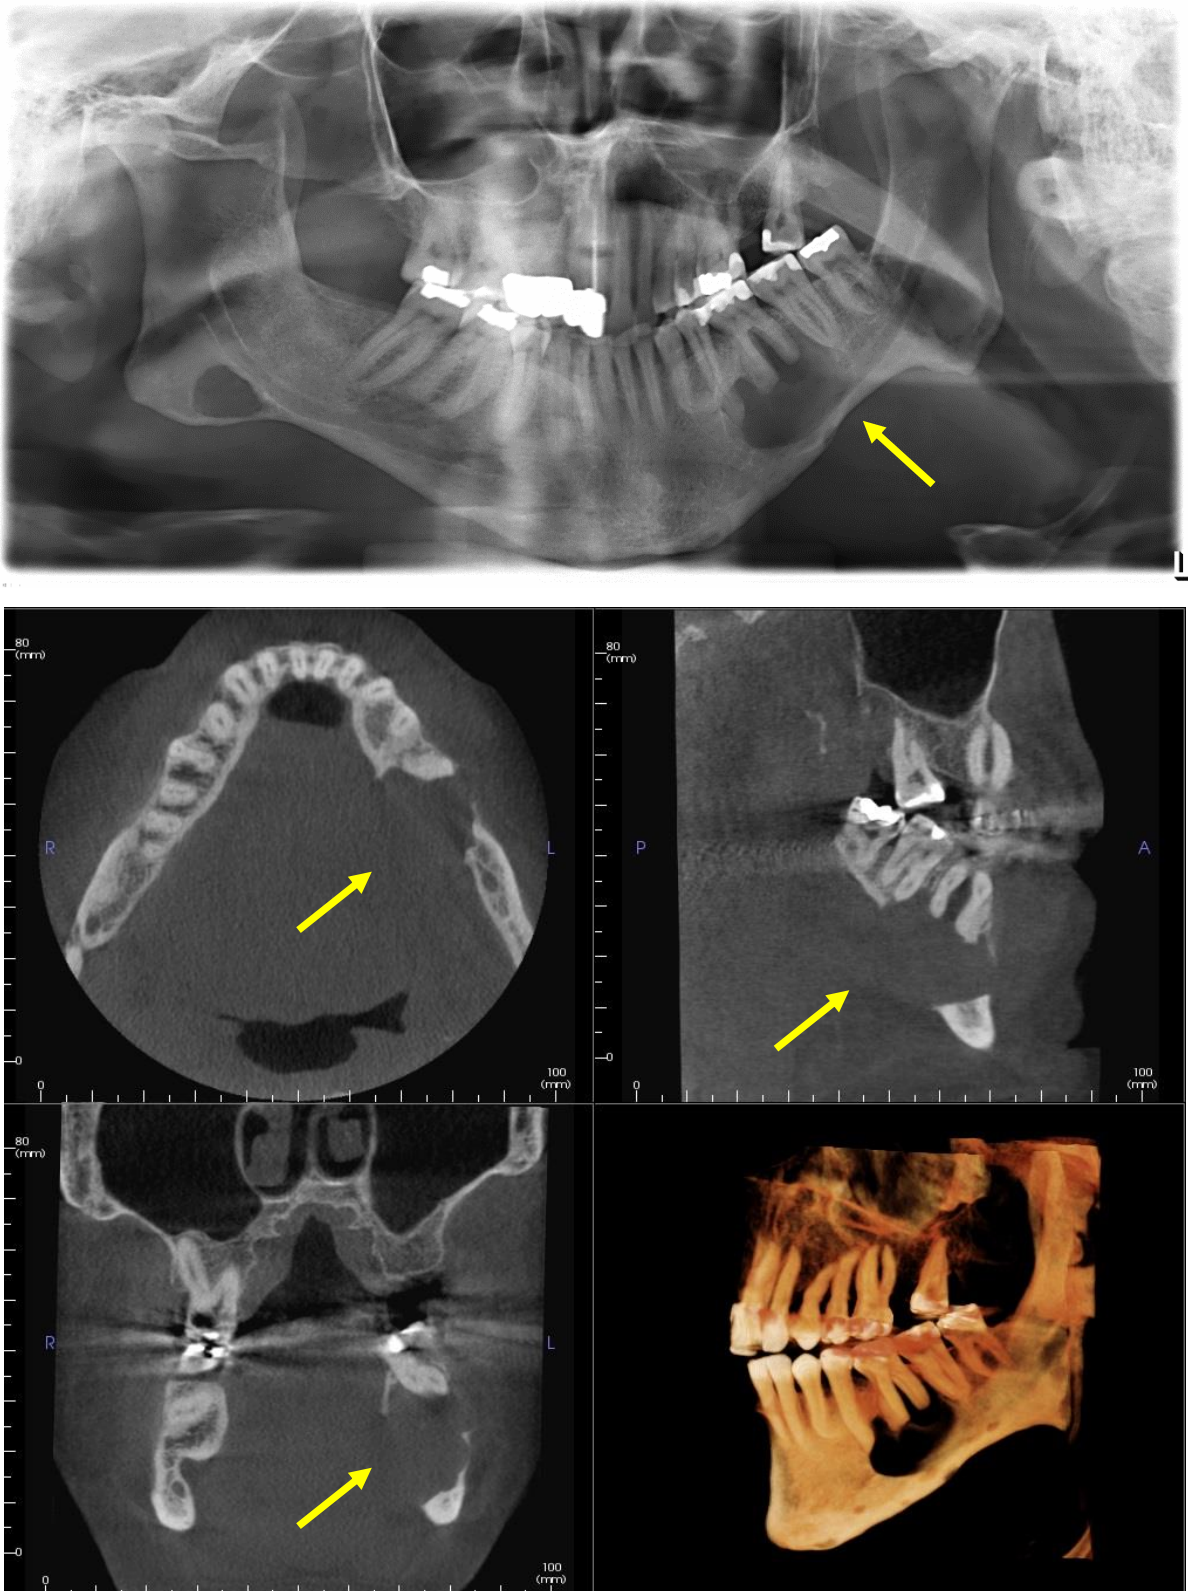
Example of CBCT demonstrating cortical thinning not seen on PAN
